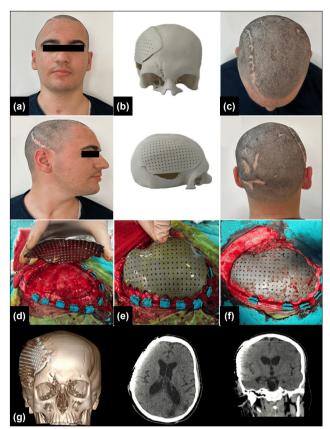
Titanium cranioplasty. a) Preoperative images of the patient from anterior and lateral views showing cranial deformity due to craniectomy. b) Sample kit produced using a 3D printer. c) Preoperative images of the patient from superior and posterior views showing previous incision scars and scalp deformities. d) Titanium plate and cranial defect area. e) Intraoperative demonstration of the fit between the implant and the defect area. f) Attachment of the dura to the implant using silk suspension sutures and fixation of the implant with predesigned plates and screws. g) Postoperative 3D and computed tomography (CT) images showing successful closure of the defect area.
